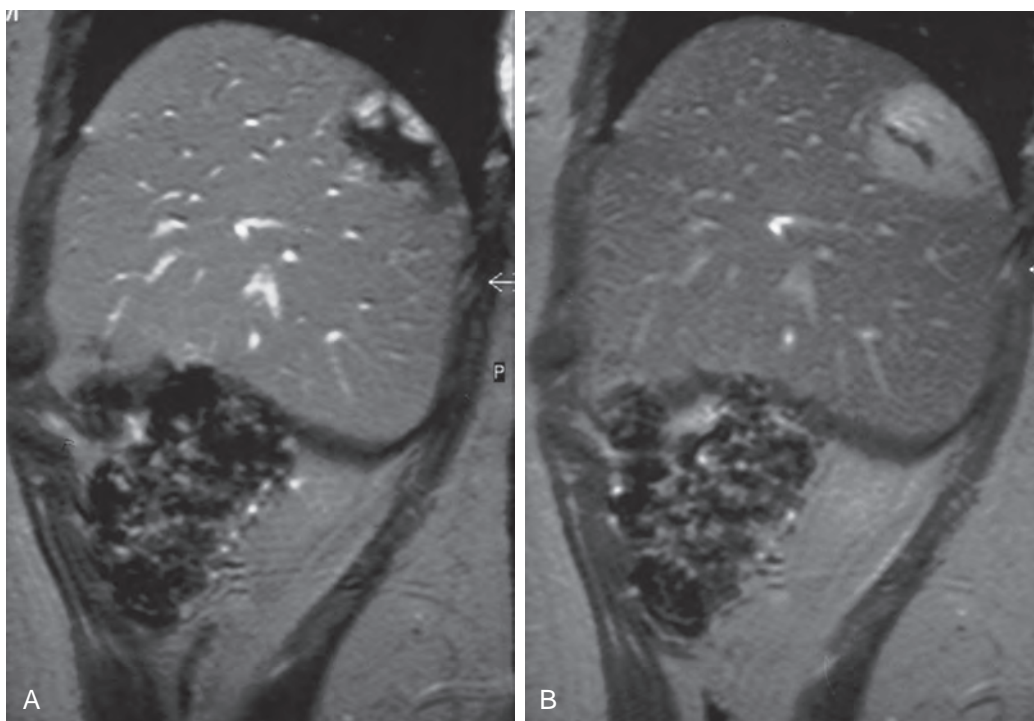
Hepatic hemangioma: MRI features. A and B. Sagittal gadolinium-enhanced images show a lesion with a central scar. Although central scars are generally associated with focal nodular hyperplasia, the contrast retention in this lesion establishes the diagnosis of a hemangioma.
